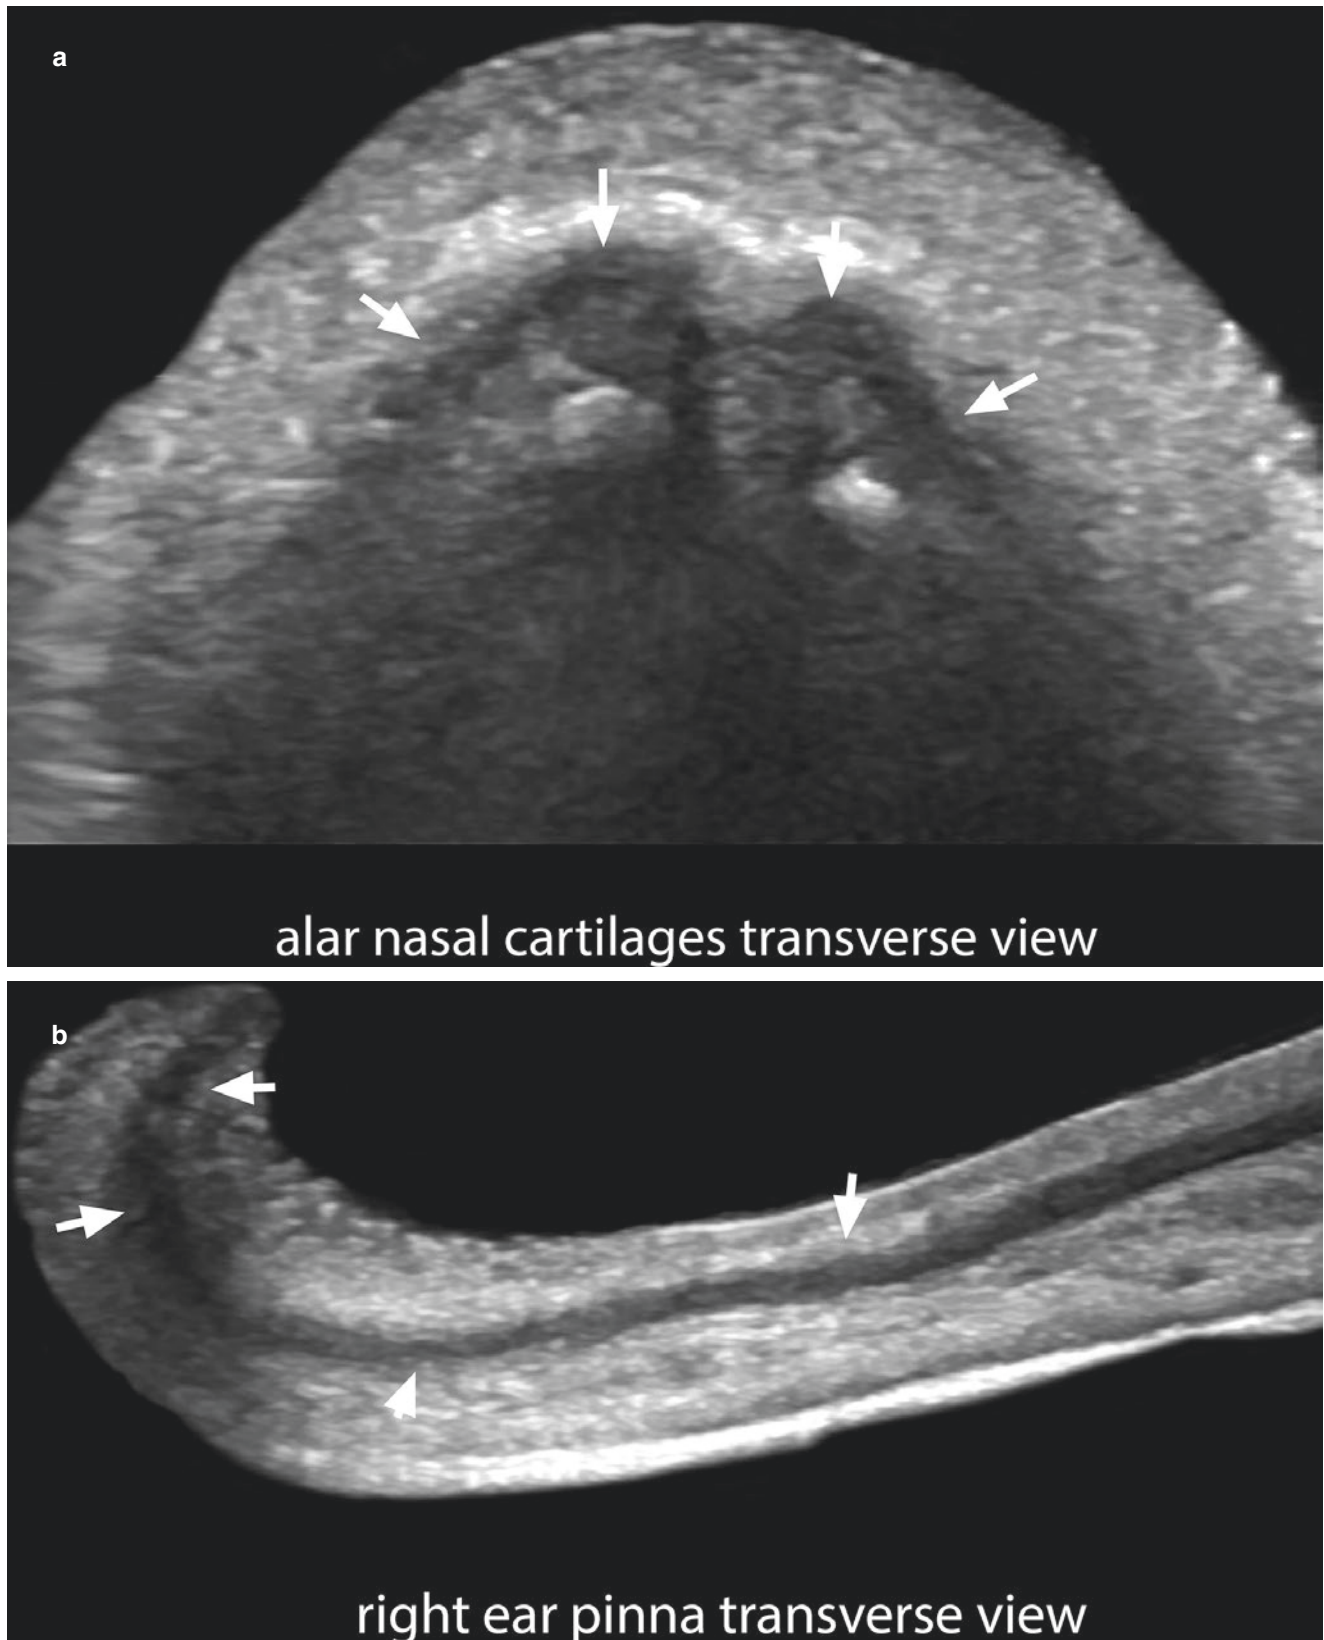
Normal ultrasound morphology of the cartilage (greyscale; transverse views). (a) Alar nasal cartilages (*arrows*) at the tip of the nose. (b) Auricular cartilage (*arrows*) of the right ear pinna. Notice the hypoechoogenicity of the cartilage pattern.
